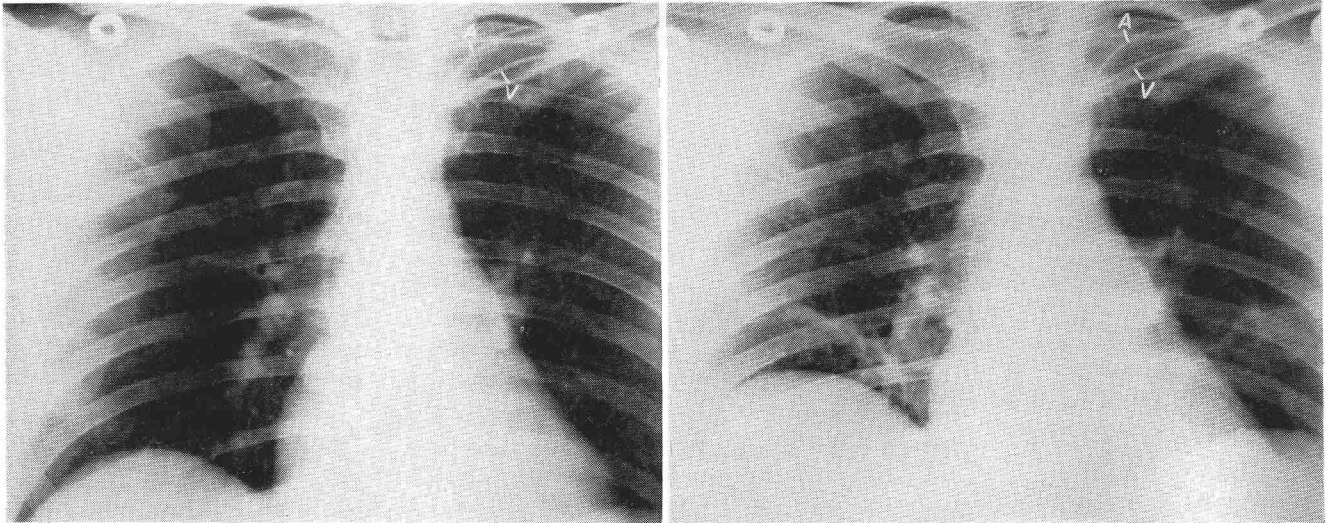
Left*: A thoracic roentgenogram of normal appearance, obtained just before the subject was accelerated to 5.5 G for 2½ min while breathing 99.6% oxygen. *Right*: A thoracic roentgenogram of the same subject after termination of the 5.5-G exposure. Note focal areas of increased density, indicative of atelectasis
